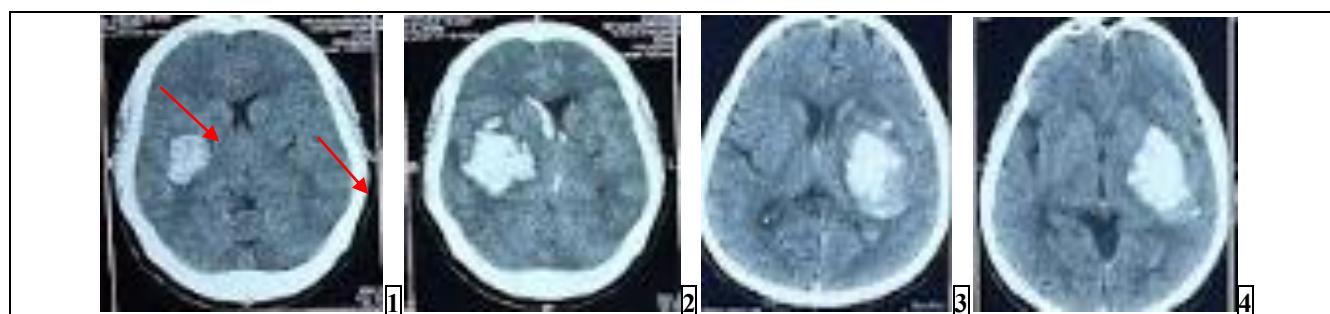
\*: (1) CT head of a patient within 6 hours of ictus showing hypodensity inside hyperdensity (arrow); (2) CT head of the same patient at around 24 hours from ictus showing significant increase in hematoma size with intraventricular extension; (3) First CT head of a patient showing blend sign;
